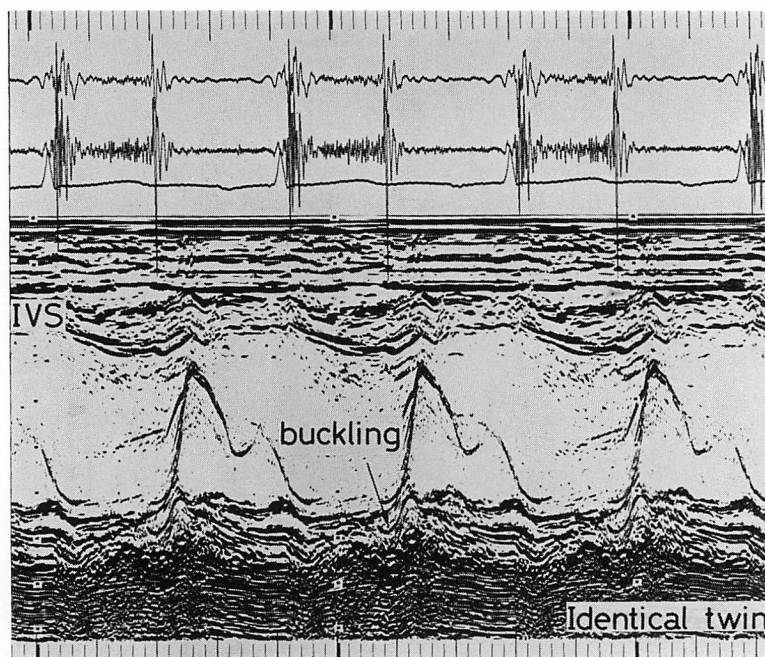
M-mode echocardiogram of the first twin.
